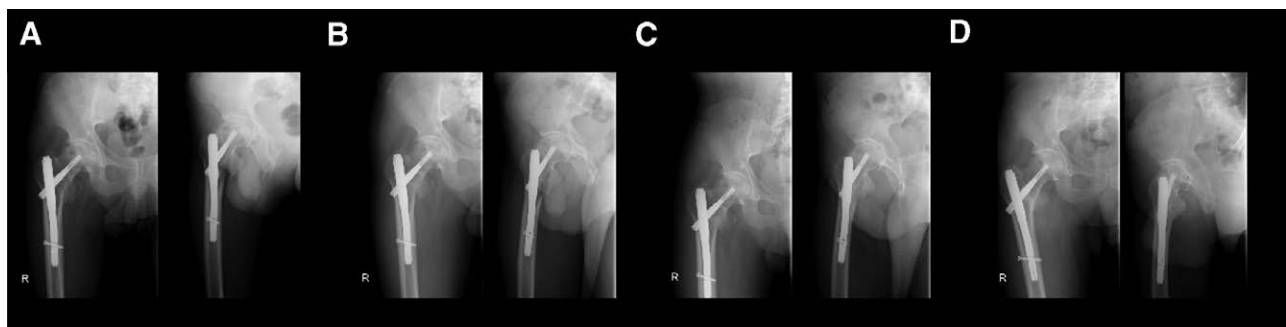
A patient who had PFNA ignored the progression of the femoral head necrosis because of the good function. (A) A 54-year-old male patient was diagnosed with right femoral head necrosis. Two years after the initial diagnosis of osteonecrosis, the patient experienced a right femoral trochanteric fracture due to an accident. The patient underwent internal fixation treatment with a proximal femoral nail to fix the trochanteric fracture. The radiograph immediately after the surgery showed necrosis of the femoral head and trochanteric fracture. (B) Three months after the internal fixation surgery of the trochanteric fracture, the radiograph showed that the trochanteric fracture was partially union. No significant progression of femoral head necrosis was identified. (C) Eight months after the internal fixation surgery of the trochanteric fracture, the radiograph showed that the trochanteric fracture was union. No significant progression of femoral head necrosis was identified. (D) Three years after the initial surgery, despite the collapse of the femoral head, the patient was pain-free without significant movement restriction. Therefore, the patient did not undergo hip arthroplasty. When asking "Are you satisfied with the initial internal fixation treatment?," the patient said "I am fine now and I am so old that I don't need a hip arthroplasty."
